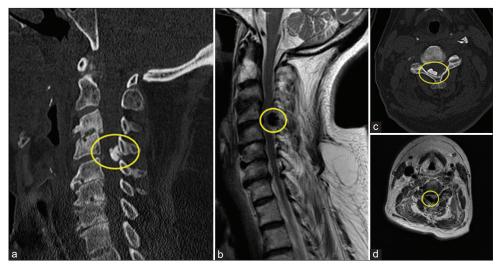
Sagittal computed tomography (CT) (a), T2-weighted magnetic resonance imaging (b), axial CT (c), and T2-weighted (d) images of calcium pyrophosphate dehydrate (CPPD) deposit disease in the cervical ligamentum flavum (CLF) of a 70-year-old female with cervical myelopathy presenting with balance and gait abnormalities experienced falls. The yellow circles (a,b,c,d) denotes a CPPD compression lesion in C4-C5 CLF lamina.
